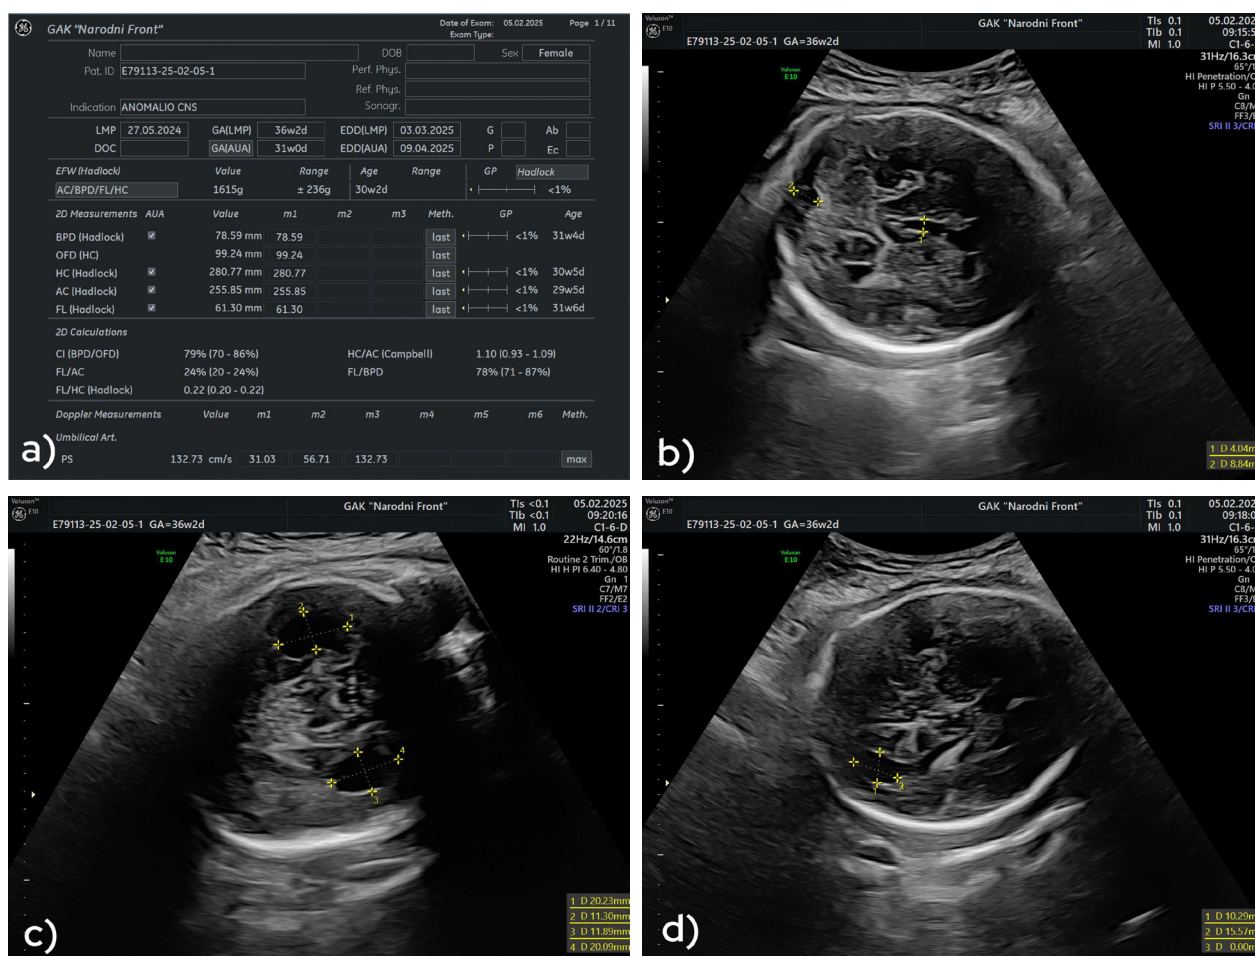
Sonographic features: a) intrauterine growth restriction; b) mild ventriculomegaly; c) dilated temporal horns of lateral ventricles; d) intraventricular septations in occipital horns of lateral ventricles.
